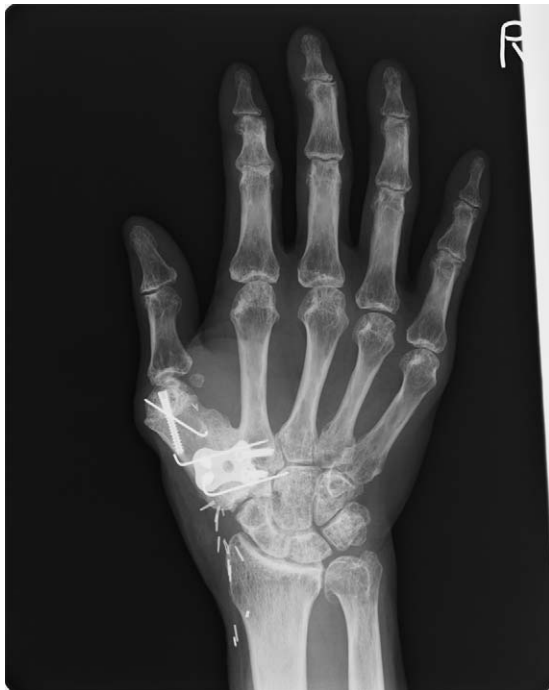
X-ray image of the right hand 12 months postoperatively. The grafted scapular bone had become united with the second metacarpal bone and trapezium.
